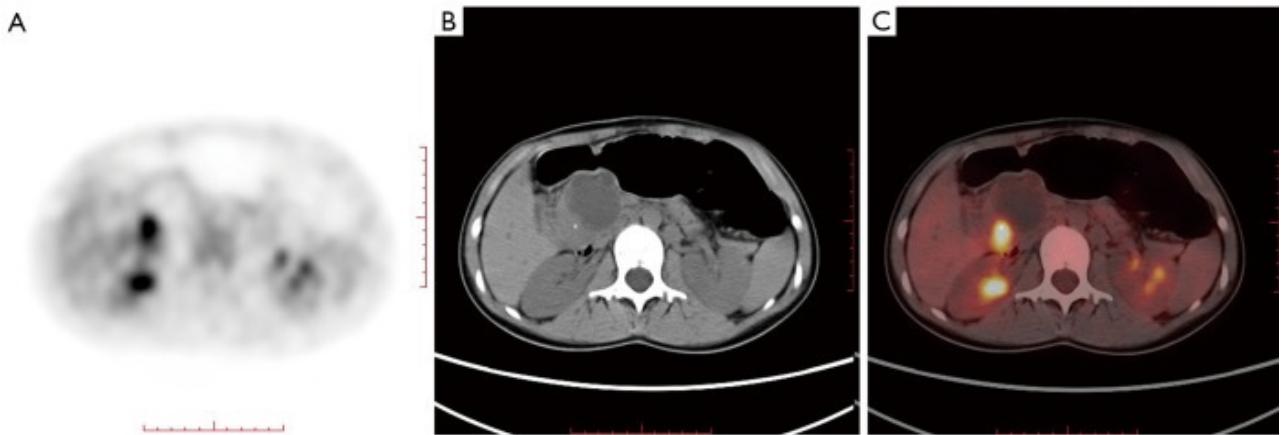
18F-FDG PET/CT imaging integrating metabolic and anatomical data: (A) PET image, (B) non-enhanced CT image, (C) fused PET and CT images, demonstrating pancreatic head cancer detection [8].
